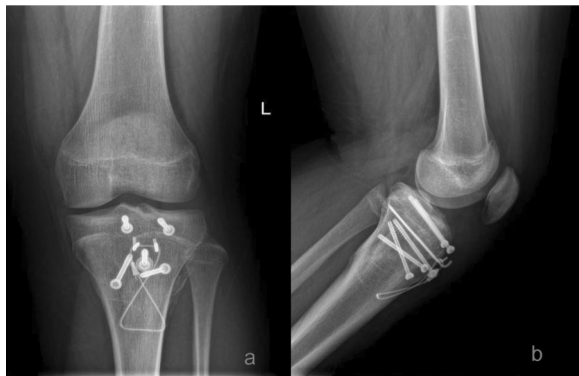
a, b Postoperative anterior–posterior (a) and lateral (b) X-ray images of the left knee showing that Ogden type V tibial tubercle avulsion fracture achieved good reduction by cannulated screws combined with tension band wiring fixation
